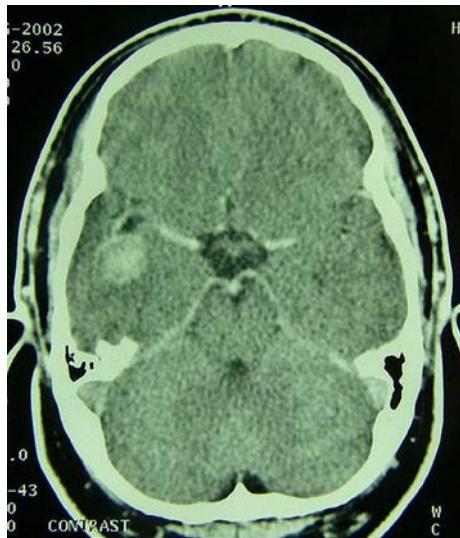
Preoperative enhanced axial computed tomographic scan reveals a round mixed high-density mass at the right distal sylvian fissure
